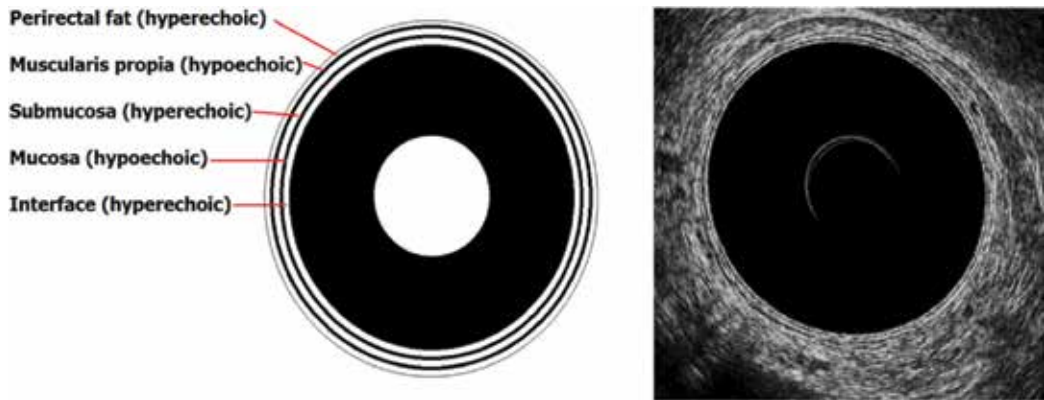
Endorectal ultrasonographic view of rectal wall (five layers).
